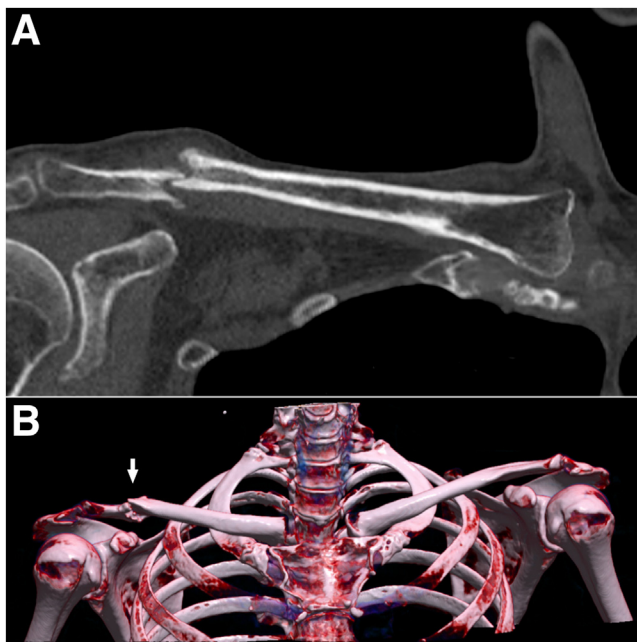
Preoperative imaging of right shoulder. (A) Two-dimensional computed tomography scan, coronal slice, highlighting selected focus of atrophic nonunion. (B) Three-dimensional computed tomography reconstruction comparing both clavicles. The right clavicle is pathological. The arrow indicates the nonunion site.
